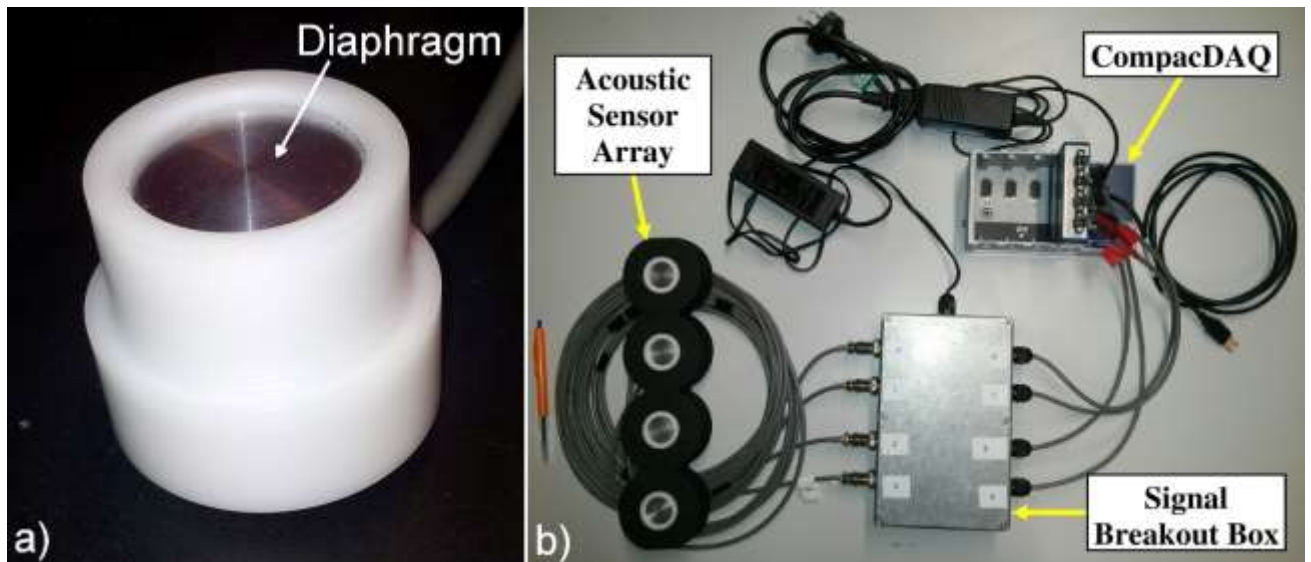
a) Assembled acoustic emission sensor and housing. Note the sensor diaphragm (visible inside the white housing) has a diameter of 25.1 mm. b) Image of data acquisition hardware which consists of four ultrasonic sensors arranged in an array, signal breakout box for external power input, and National Instruments CompacDAQ (A ball-point pen of length 140mm has been included at the left of the image for scale).
